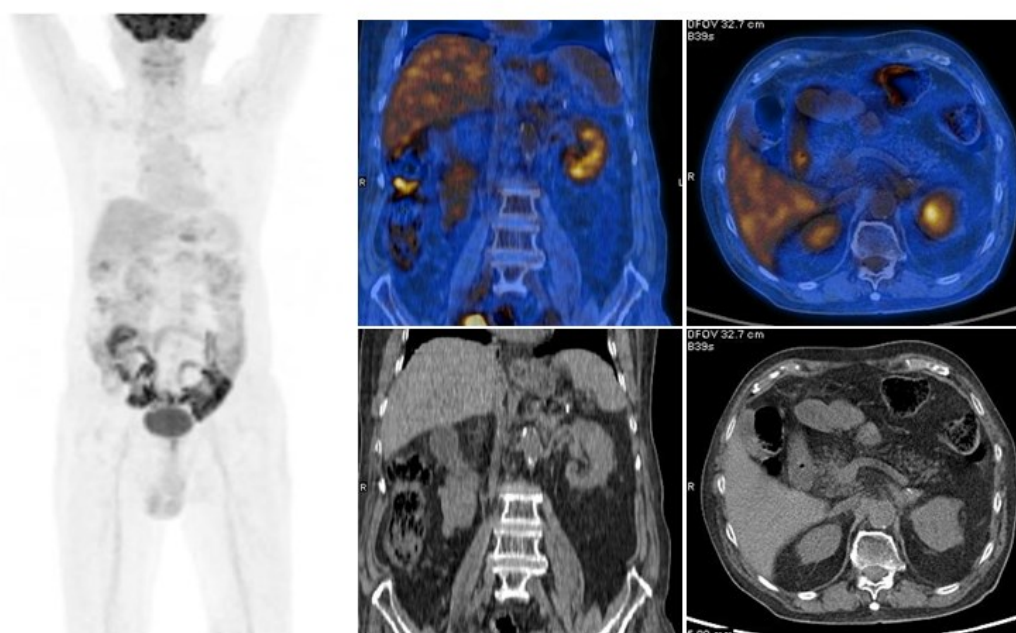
[^{18}F]FDG PET/CT image obtained 6 months after treatment shows normal physiological biodistribution of [^{18}F]FDG throughout the body. No abnormal uptake is observed in the adrenal bed, indicating complete metabolic response to treatment
